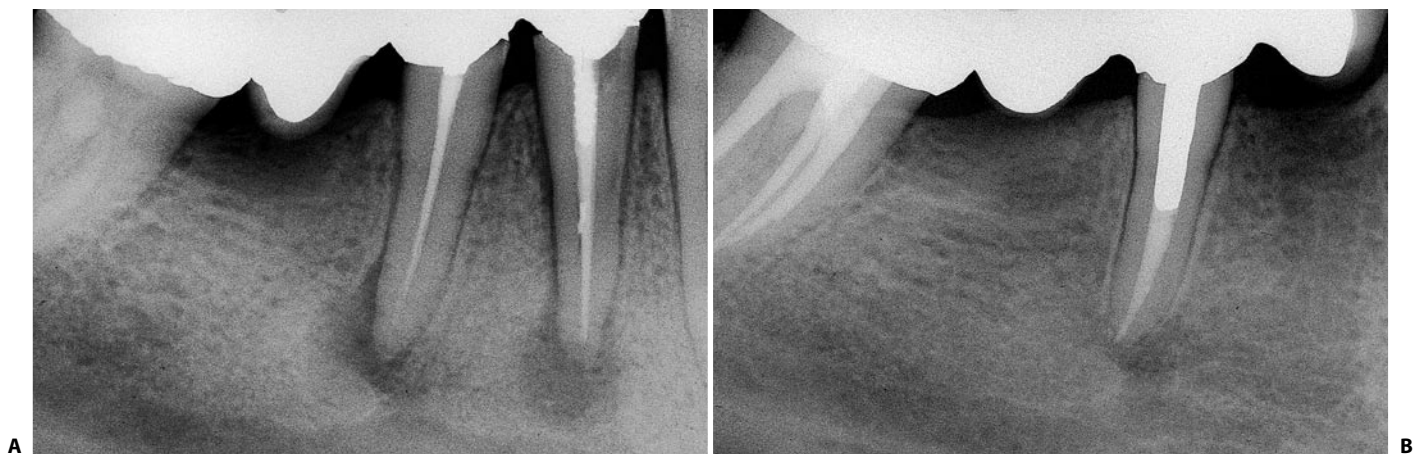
A. A radiolucency is present at the apex of both the first and the second lower premolars, which appear to be underfilled. The first premolar also shows a wider periodontal ligament space on the distal aspect, a screw post, an empty space between the dentin and the obturating material apical to the screw post. Clinically, there is a deep and narrow probing defect: the tooth has a vertical root fracture and therefore has to be extracted. B. The 3 year recall radiograph shows the complete healing of the two lesions, both where a non surgical retreatment has been performed as well as where the tooth has been extracted. In both cases the same final result has been accomplished: the complete elimination of the infected root canal system.
